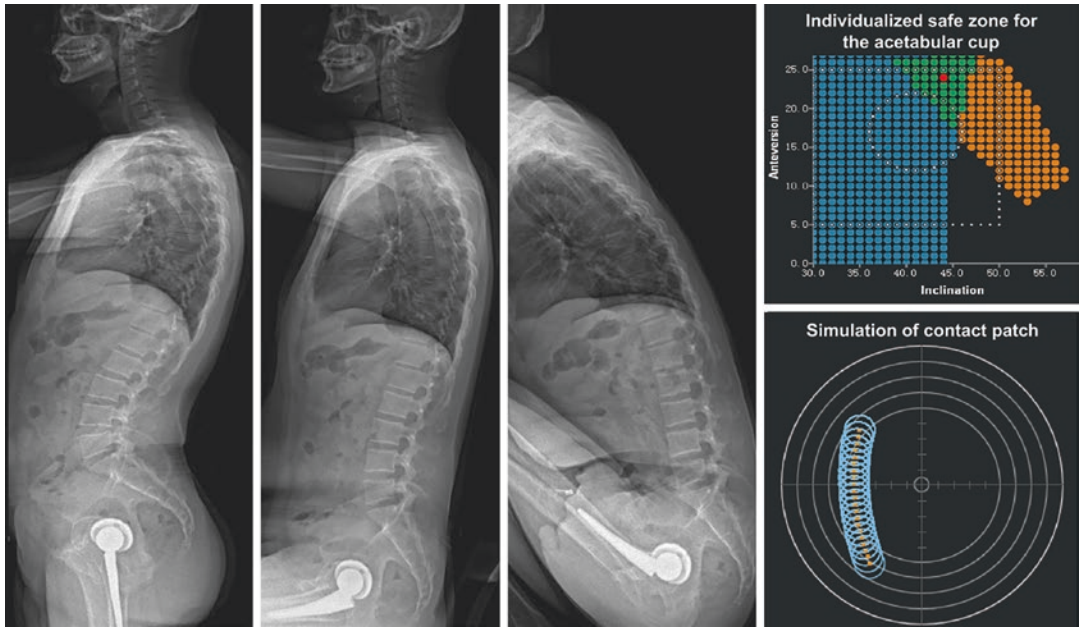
The postoperative radiographic evaluation of standing, sitting, and squatting positions with the corresponding patient-specific safe zone and the pathway of head-cup contact Patch during flexion
